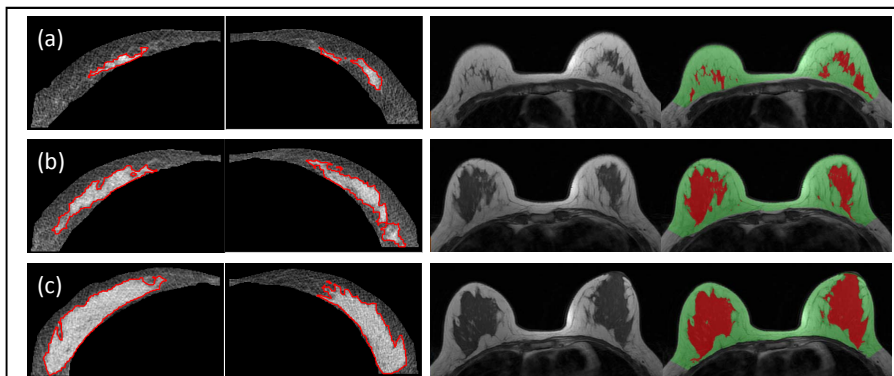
Example of low dose CT and MRI showing different densities. (a) a fatty breast, BV= 1411 cc, FV= 28.5 cc, PD= 2.0 %; (b) a moderate dense breast, BV= 1006 cc, FV= 176 cc, PD= 17.5 %; (c) an extreme dense breast, BV= 1045 cc, FV= 370 cc, PD= 35.4 %.
